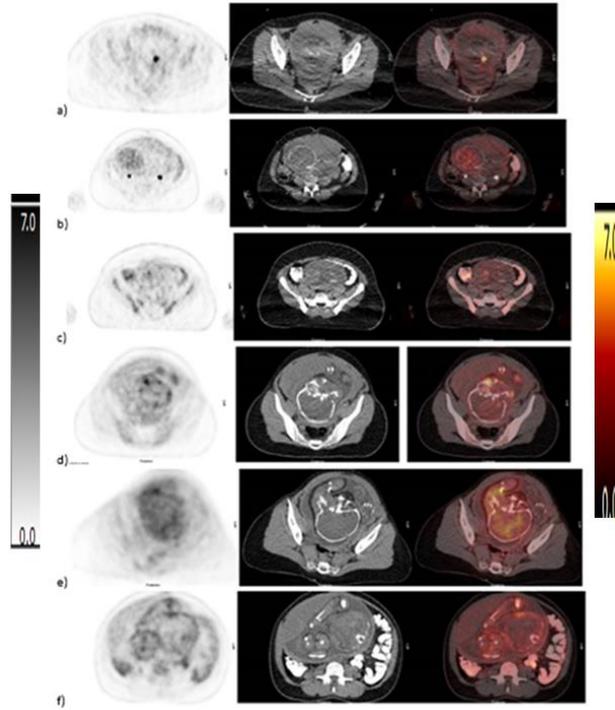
Examples of a single PET, CT and PET/CT fused image for 6 patients in the cohort at gestational age of a) 12 weeks with high concentration of ^{18}F -FDG in the fetal heart b-c) 20 weeks, d-f) 36 weeks to demonstrate 1st trimester, 2nd trimester, and 3rd trimester pregnancy, respectively. The ^{18}F -FDG uptake in the fetus is seen in the PET images.
